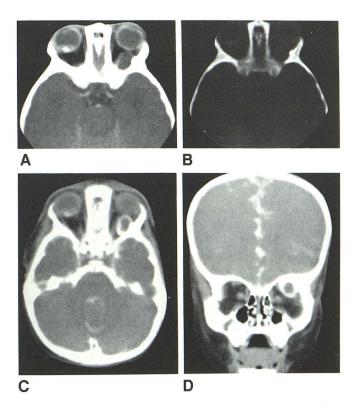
A, Axial CT scan. Calcified lesion of retinoblastoma in right globe. Low-density (18 H) mass in superolateral left orbit displacing optic nerve medially. B, Same scan with bone density setting. Hyperostosis of lateral orbital wall adjacent to lesion. Slight widening of superior orbital fissure. C, Axial metrizamide CT cisternogram. Rim of contrast around left orbital lesion. D, Coronal view. Lesion completely separate from optic nerve.
